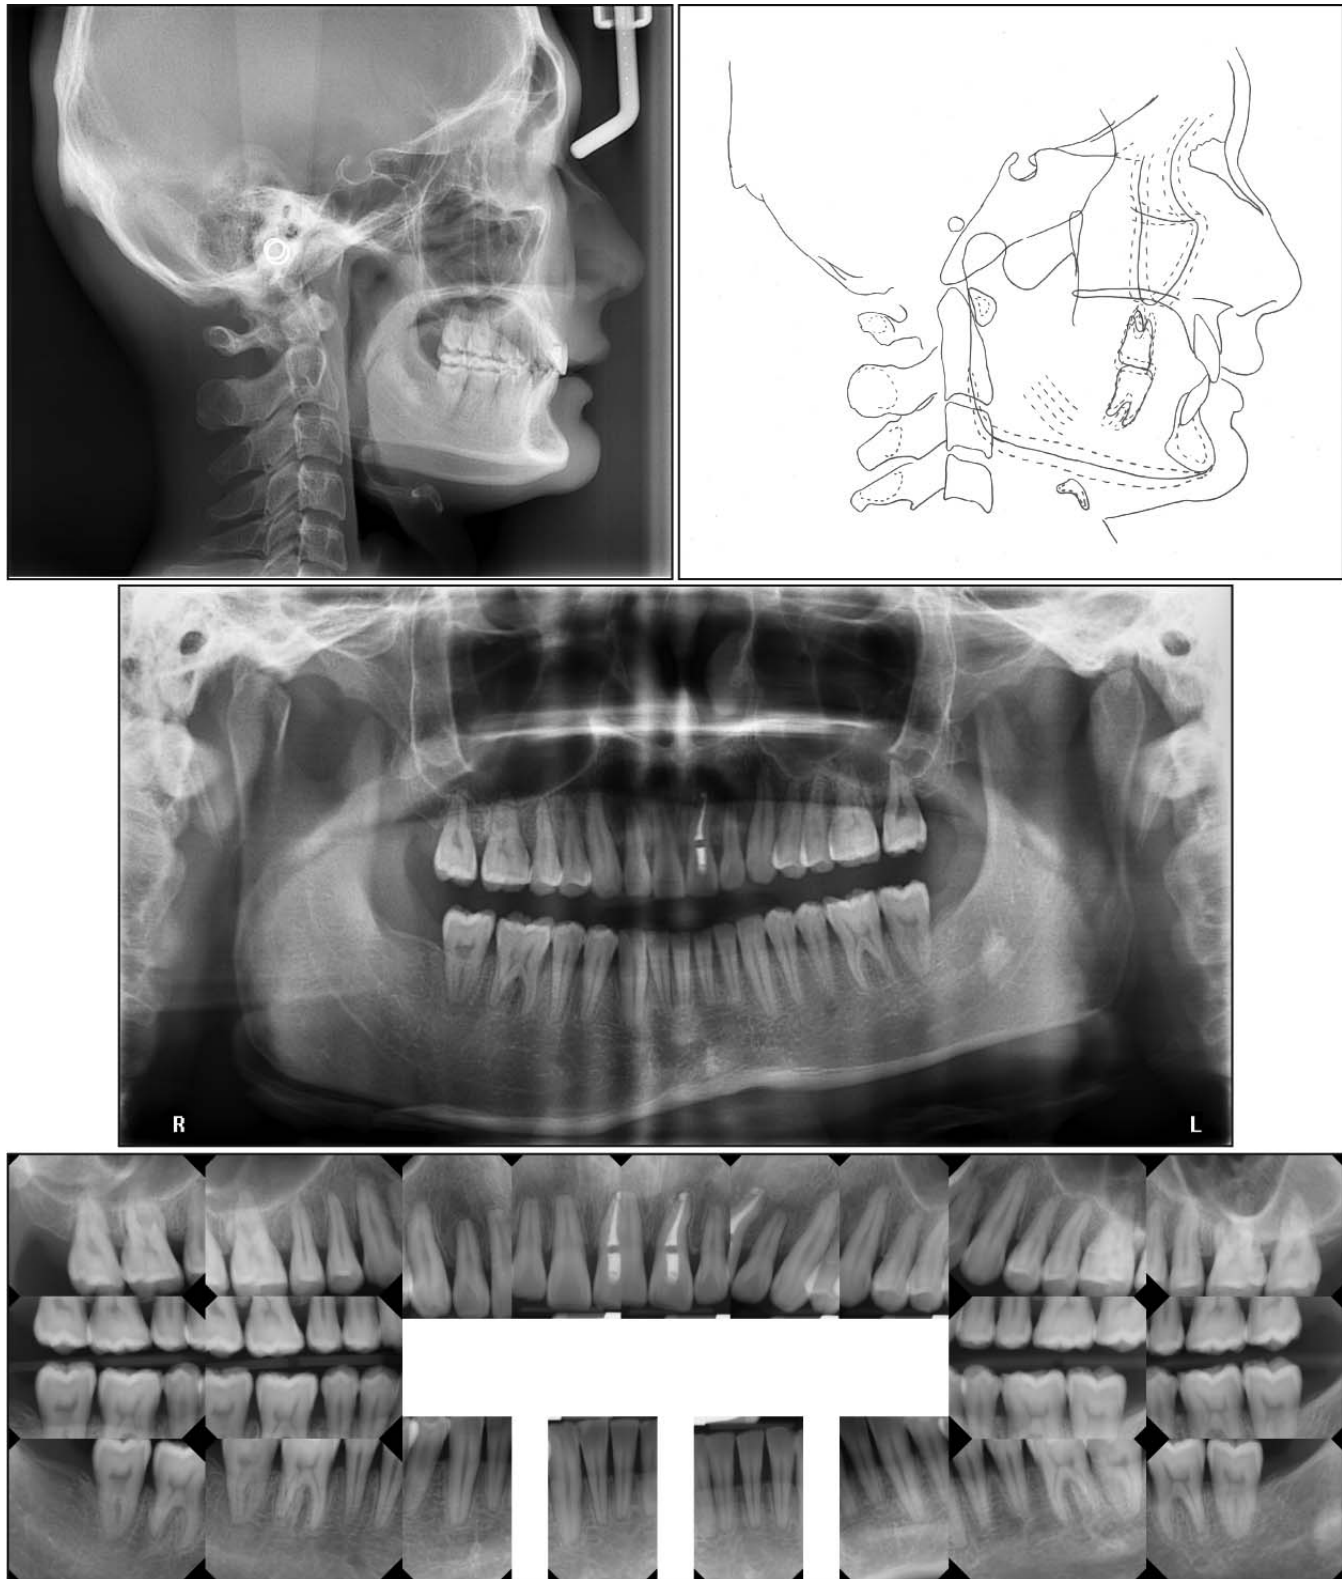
Posttreatment lateral cephalometric radiograph, cephalometric tracing, panoramic radiograph, and full-mouth series x-rays.
